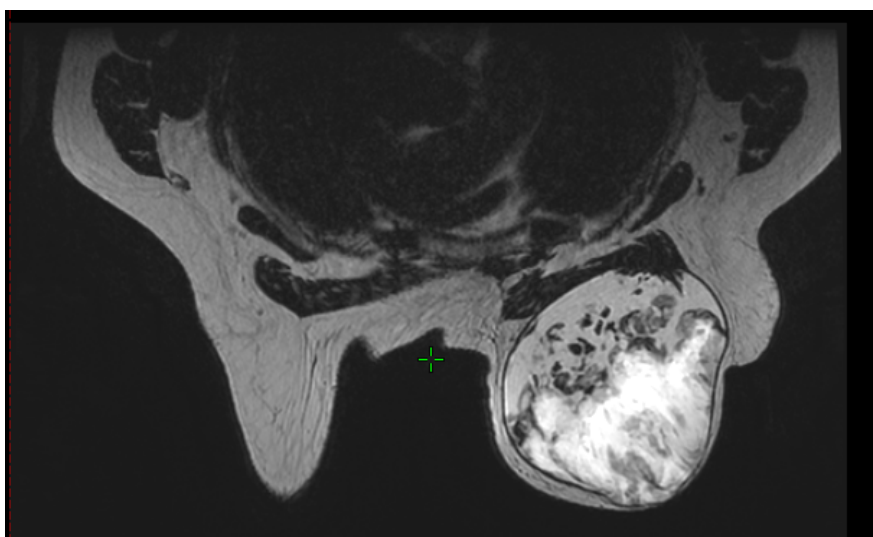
T2-weighted breast MRI showing a mass in the left breast with heterogeneous signal intensity, cystic components, and internal septa.
